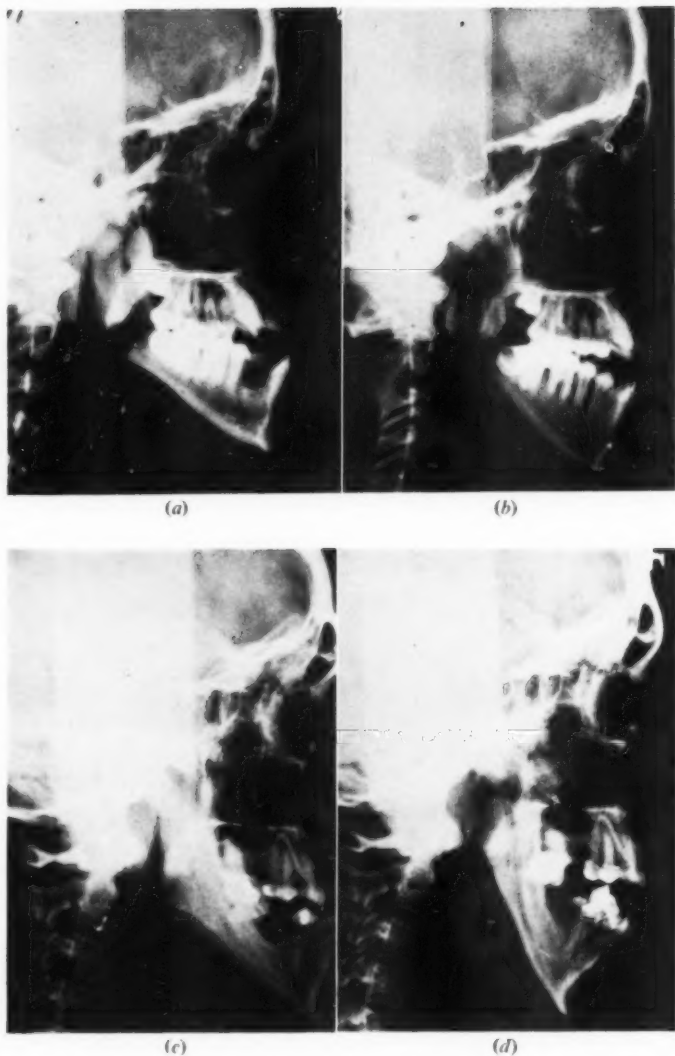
(a) Pre-operative X-ray showing anterior open bite. (b) Post-operative X-ray showing increased anterior open bite after a blind ascending ramus slide. (c) Pre-operative X-ray showing no anterior open bite. (d) Post-operative X-ray showing severe anterior open bite after a blind ascending ramus slide.
